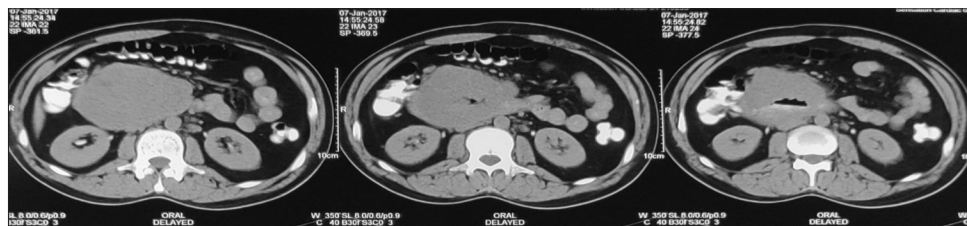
CT scan done in January 2017
